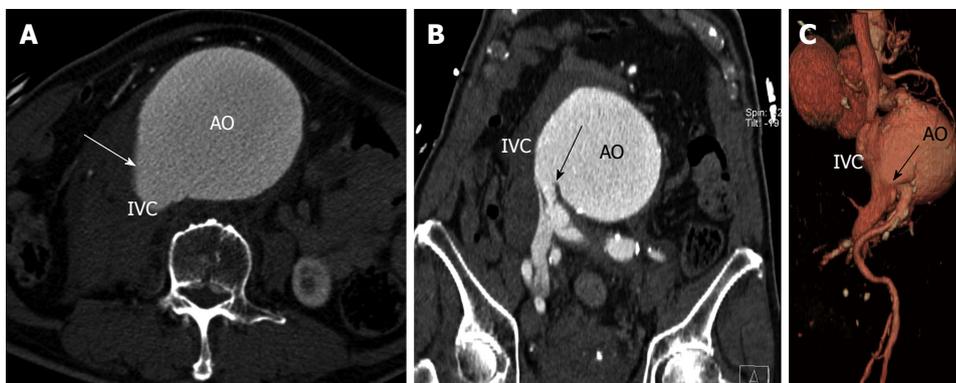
Aorta to inferior vena cava fistula. A: Axial contrast computed tomography (CT) of the abdomen in a patient with history of abdominal aortic aneurysm (AO) shows similar contrast opacification of the inferior vena cava (IVC). There is a communication demonstrated (arrow) between the aorta and IVC; B: Coronal contrast CT of the abdomen demonstrates the site of fistulous communication between the aorta and the distal IVC adjacent to the right common iliac vein; C: Volume rendered 3D computed tomography angiography shows fistulous communication (arrow) between the abdominal aorta and IVC.
